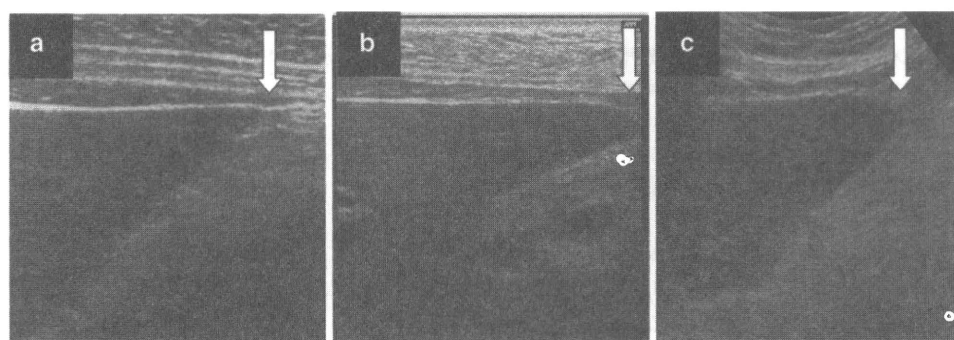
Results for the ultrasonographic features of the liver surface; a a smooth surface with a high-frequency probe, b a mildly irregular surface with a high-frequency probe, c an irregular surface with a low-frequency probe, and d a highly irregular surface with a low-frequency probe
